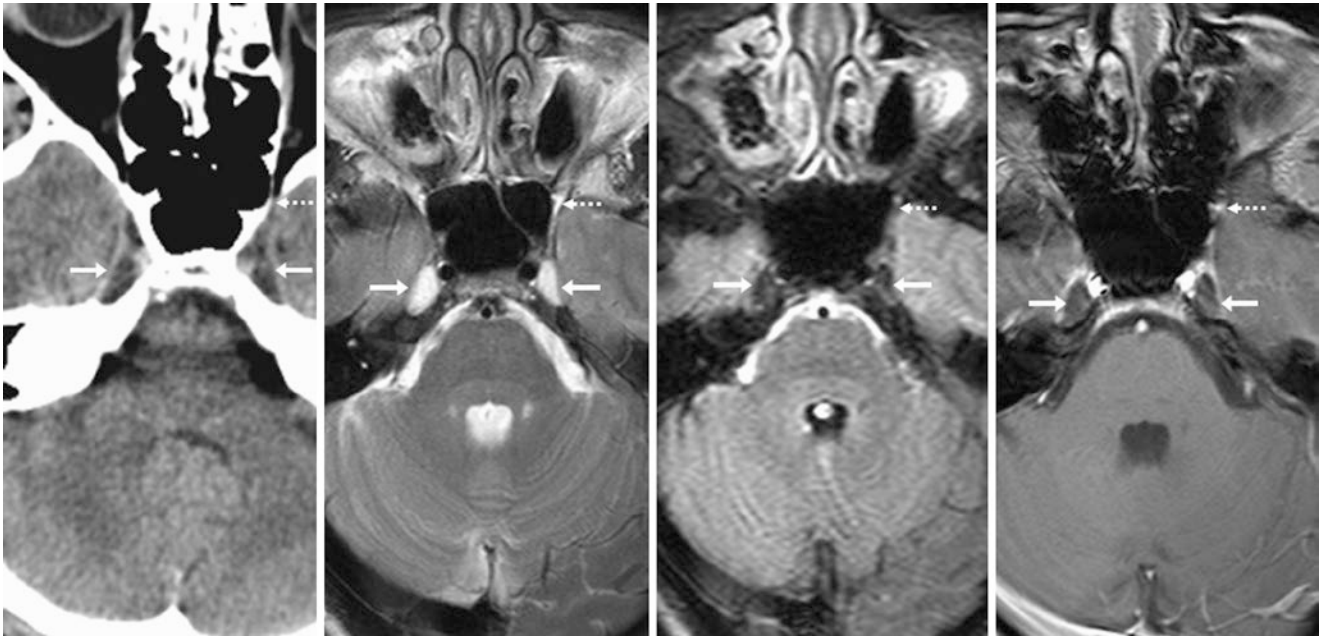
A 57-year-old patient with a non-enhanced CT (NECT) (*left*) and 3 T MRI axial T2WI (*left middle*), FLAIR (*right middle*), and post-contrast T1WI (*right*) that demonstrate mildly prominent subarachnoid spaces in Meckel caves bilaterally surrounding the trigeminal ganglia
